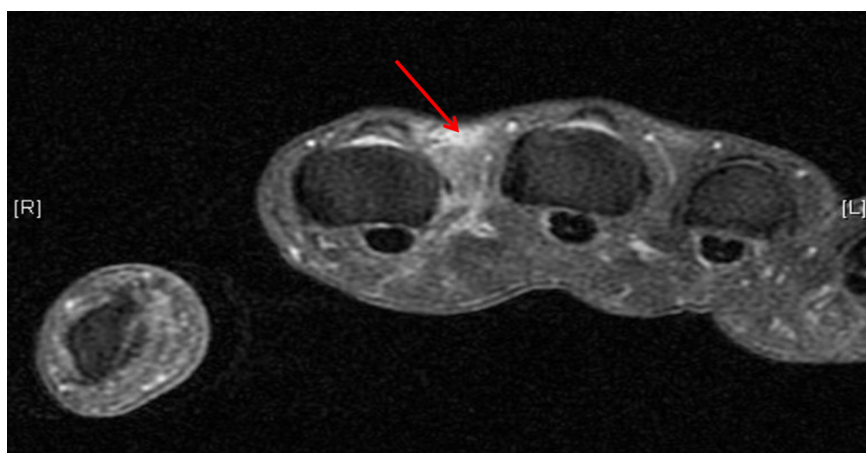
Axial MRI scan confirming injury to ulnar sagittal band (red arrow) in Case 2.
